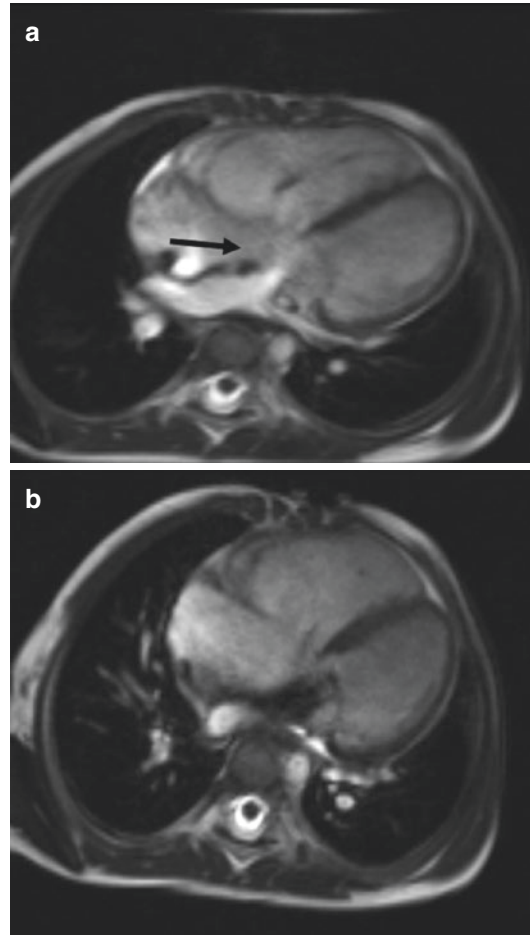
Partial atrioventricular septal defect. (a), (b) Four-chamber view images obtained from cine FLASH MRI sequence demonstrate mitral and tricuspid valves at the same level due to the common ring, ostium primum ASD (black arrow) and mitral regurgitation
